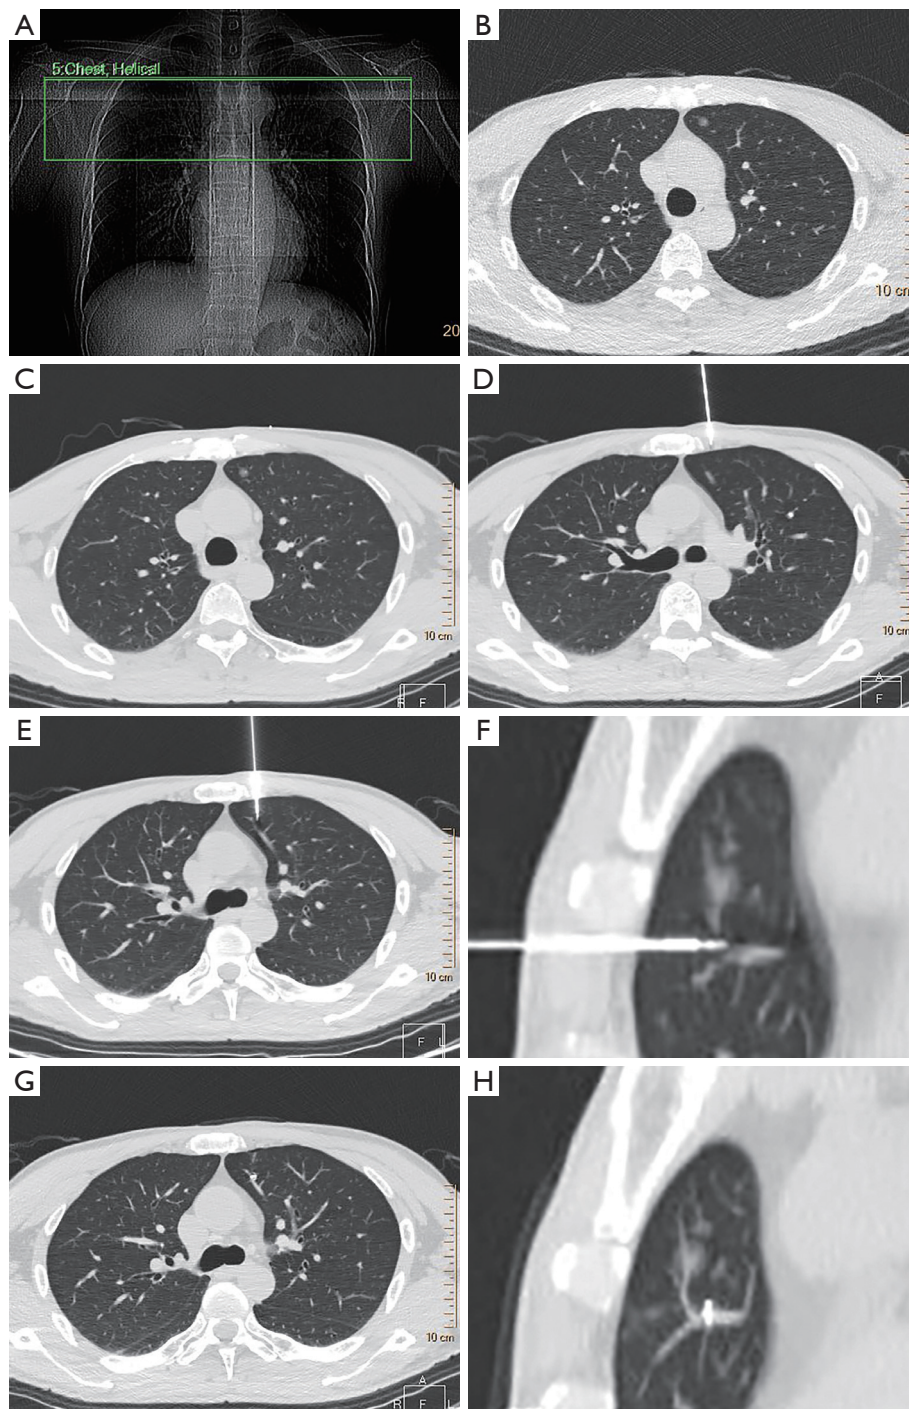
Low-dose CT-guided localization map of a 56-year-old male patient. (A) The green frame is the local scanning area analyzed during the puncture localization process. (B) The ground-glass density nodules were located in the left upper lobe. (C) The metal marker point was located in the anterior chest wall to designate the local anesthesia and puncture needle insertion path. (D) After local anesthesia, the puncture needle was inserted into the chest wall, and the angle and length of needle insertion were identified by local scanning. Because the needle tip did not reach the pleura, it was easy to adjust and avoid complications such as pneumothorax and intrapulmonary hemorrhage. (E) The puncture needle passed into the lung but did not enter the nodule. (F) The sagittal image shows the needle located within 1 cm below the nodule. (G,H) The metal hook wire was successfully positioned as confirmed by a repeat scan after the end of localization. Minimal pneumothorax at the puncture site should be noted. CT, computed tomography.
